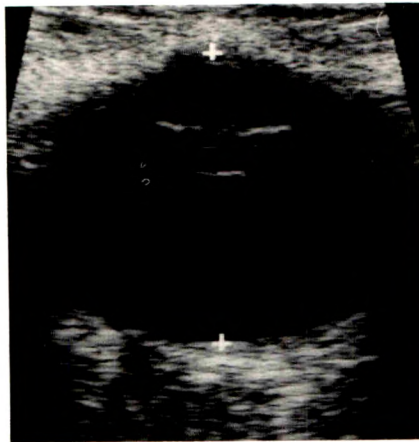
Posterior dislocation of lens. Sonogram obtained after blow to eye shows lens is situated more posteriorly than normal relative to iris plane, which makes anterior chamber unusually deep.
